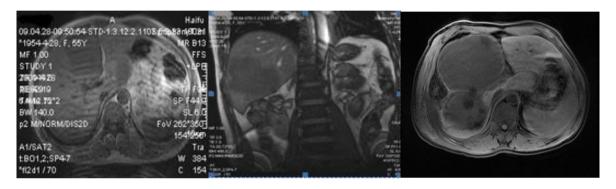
MRI after HIFU treatment showing the same cysts as in Figure 1, (a) the volume of the cyst (arrow) is reduced, the boundary is now indistinct, and the signal intensity has become more uniform, (b) coronal plane image showing that the cyst (arrow) volume is smaller than before treatment, and the signal intensity is increased and more uniform, and (c) the cyst (top arrow) volume has decreased, the boundary is now indistinct, the volumes and number of small vesicles (bottom arrow) are both reduced, and the number of vesicles decreased.
